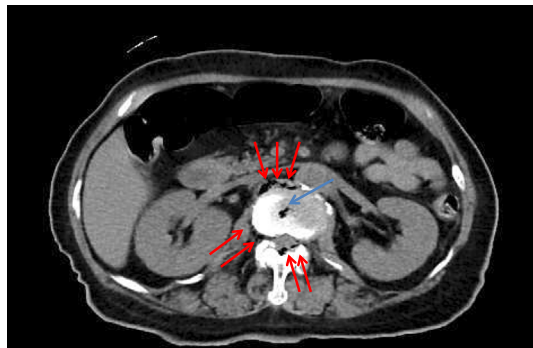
Computed tomography image of the abdomen showing emphysematous lesions around the spine (red arrows) as well as the presence of intraosseous air (blue arrows).
